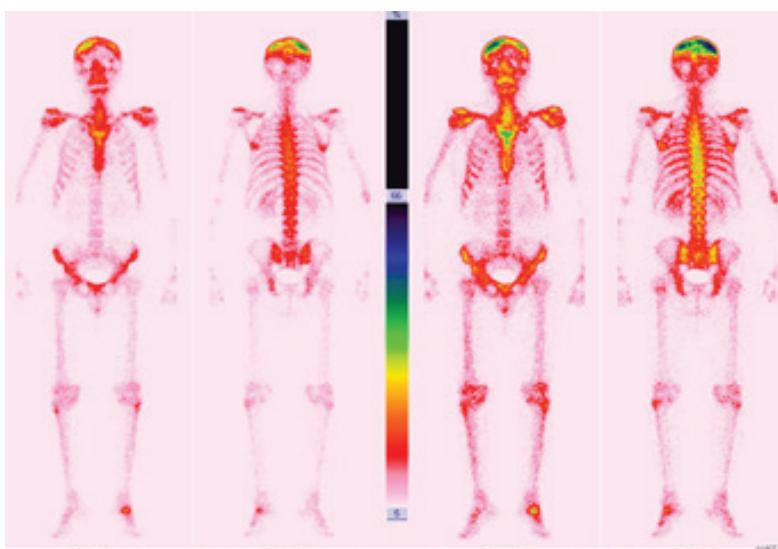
Bone scintigraphy showing hyperfixation in the right parietal bone
